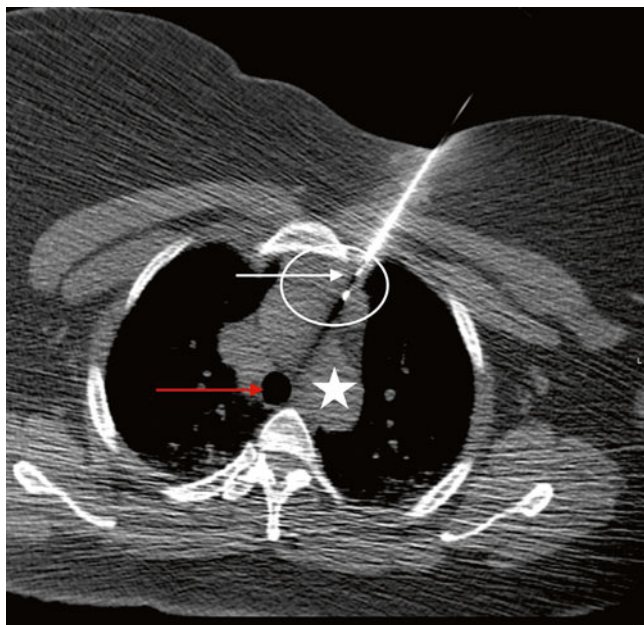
CT-guided mediastinal mass biopsy. This image shows needle (*white arrow*) placement within an anterior mediastinal mass (*white circle*). Note the proximity of the mass and the needle to the aortic arch (*white star*) and the trachea (*red arrow*). Active imaging guidance during such a procedure reduces risk of injury to such vital structures
